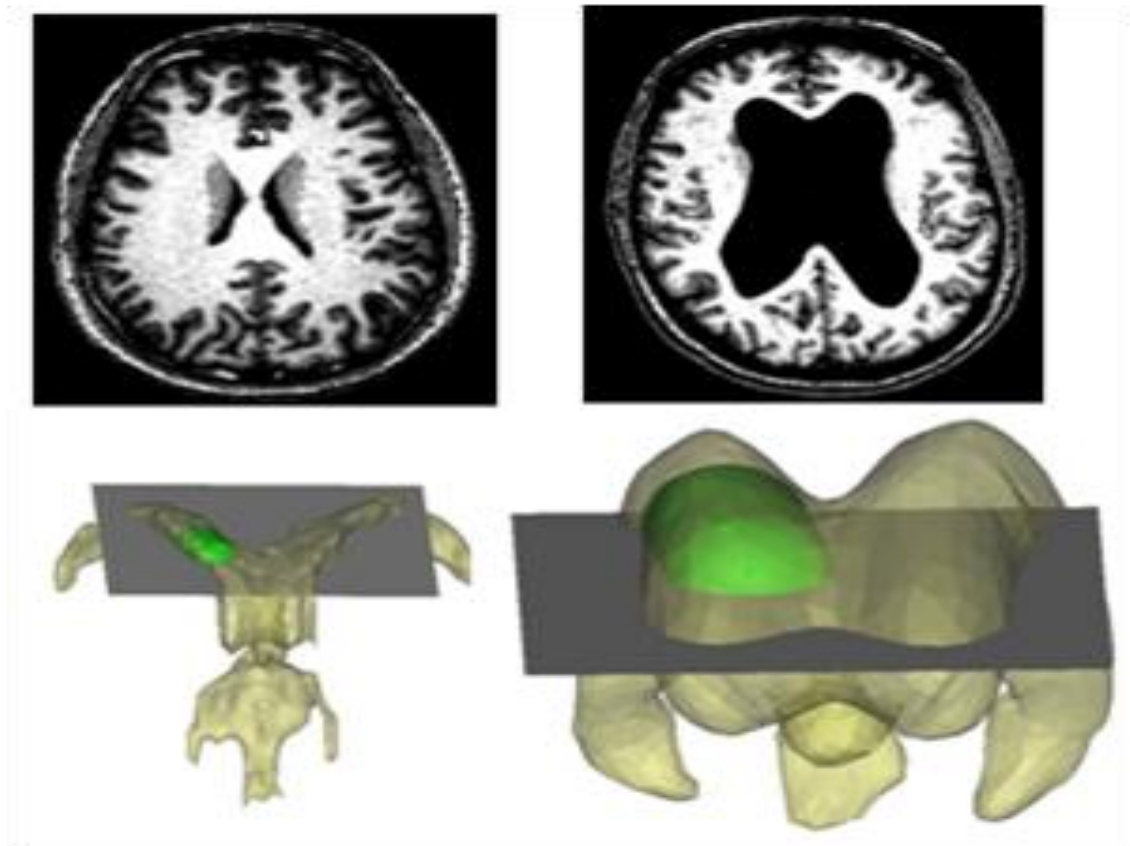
Two dimension MRI and three dimensional reconstructions. Bench-top models with dimensions similar to the green ellipsoid are used to emulate ventricular enlargement.
